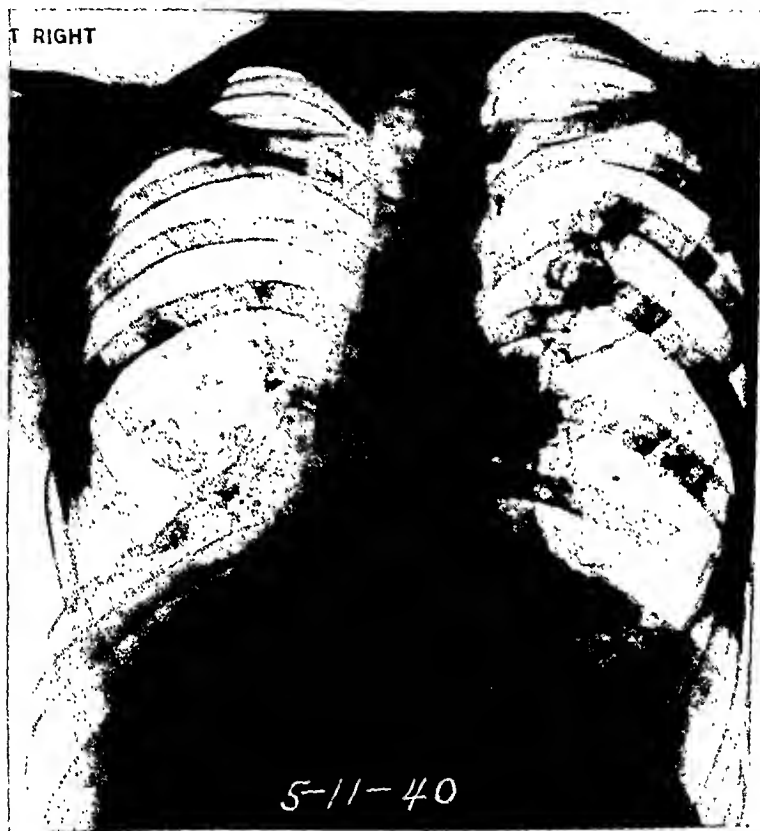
X-ray film at time of discharge after last operation.
